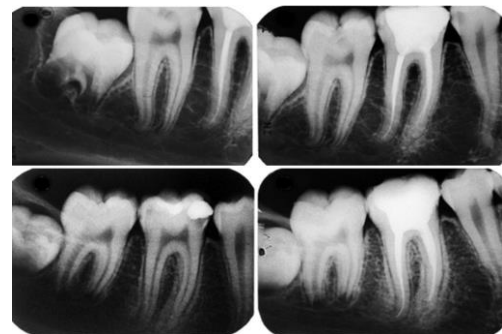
Comparison between (a and b) postmortem (2011) and (c and d) ante-mortem (2009) periapical radiographs, revealing endodontic treatment in the mandibular right first molar; dilaceration of the mandibular right second premolar; and incomplete root formation in the mandibular right third molar
